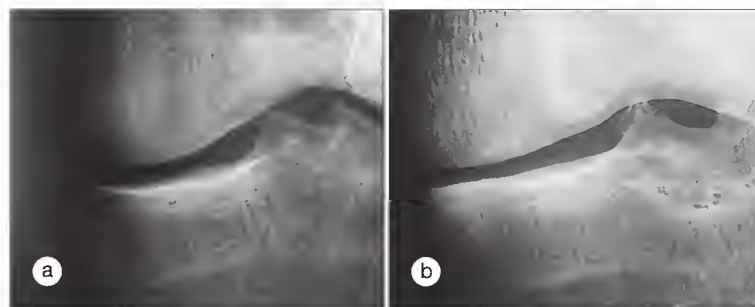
Radiographic progression of osteoarthritis. Part of macroradiographs (reduced) showing the medial compartment in osteoarthritic knees. (a) Early disease: joint space width greater than 3 mm. (b) Definite disease: joint space width less than 3 mm. With progressive joint space loss, note the increase in subchondral cortical plate thickness and subjacent horizontal trabeculae, which results in a ladderlike appearance that is enhanced by subarticular osteoporosis. Periarticular osteopenia in (a) adjacent to the developing marginal osteophyte is not visible in (b), because osteophytic growth appears to have halted. Osteophytes at the tibial spines appear as irregular outgrowths in (a) and (b). A marginal osteophyte is visible at the posterior rim of the tibia in (b).
